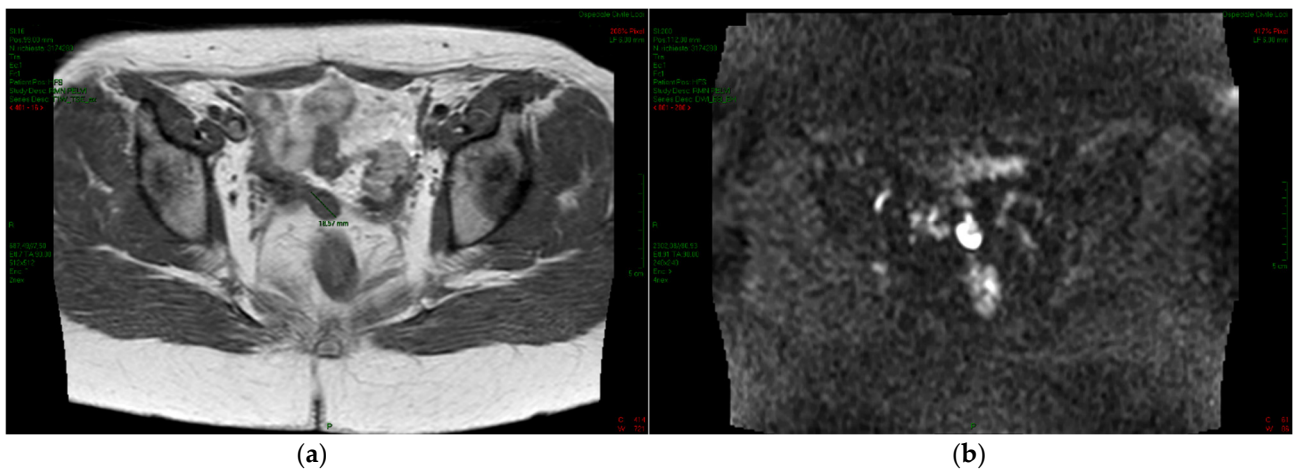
Magnetic resonance. A solid mass is identified as an 18 mm nodule located above the vaginal cuff with intermediate signal intensity on T1 TSE-weighted axial imaging (a) and with high signal intensity on diffusion-weighted MRI (b), suggesting the presence of a highly cellular lesion.
